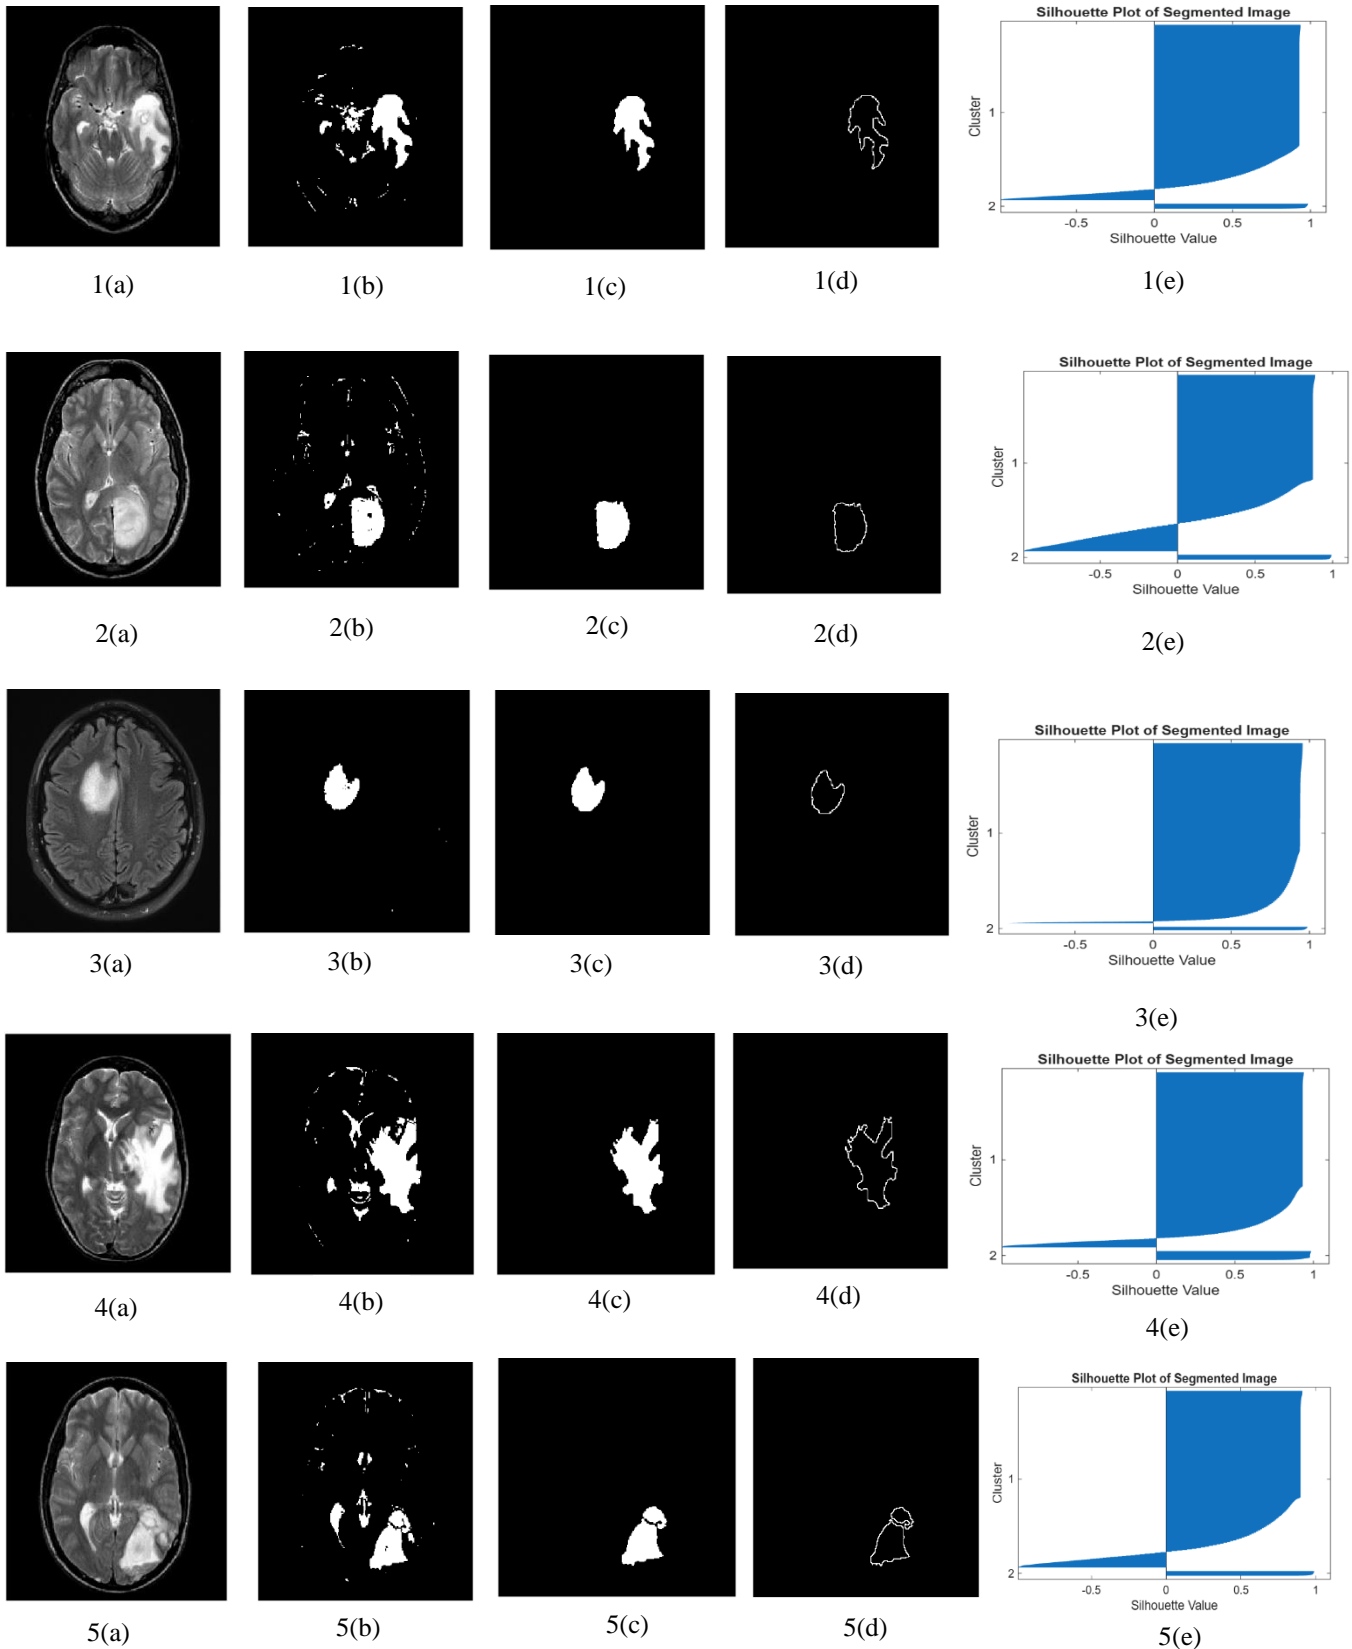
Qualitative results of the proposed method on five test images, each shown in five stages: (a) original MRI brain scan, (b) thresholded image, (c) segmented tumor, (d) tumor boundary, and (e) Silhouette Coefficient representation
